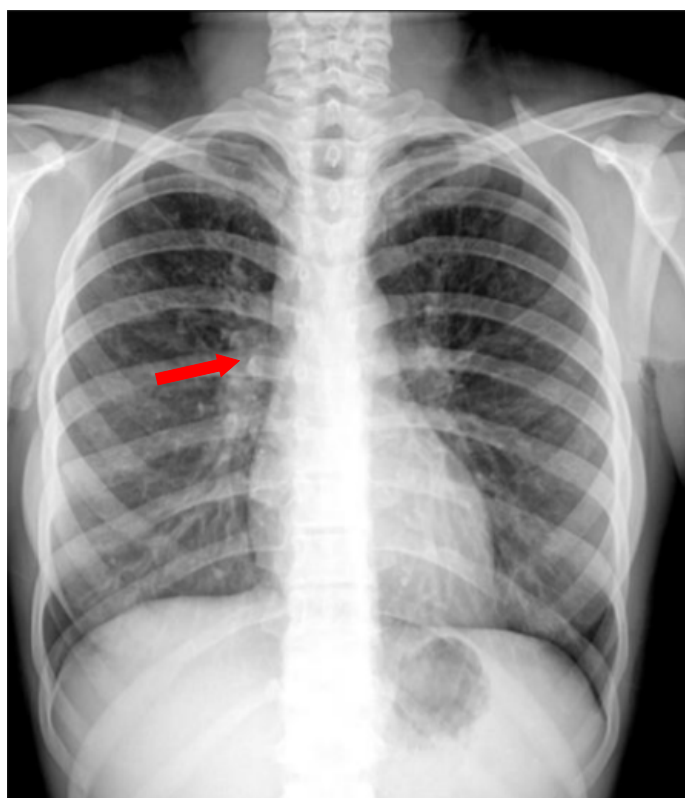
Enlargement of bilateral upper-middle zones and train rail appearance on PA chest X-ray (red arrow).
